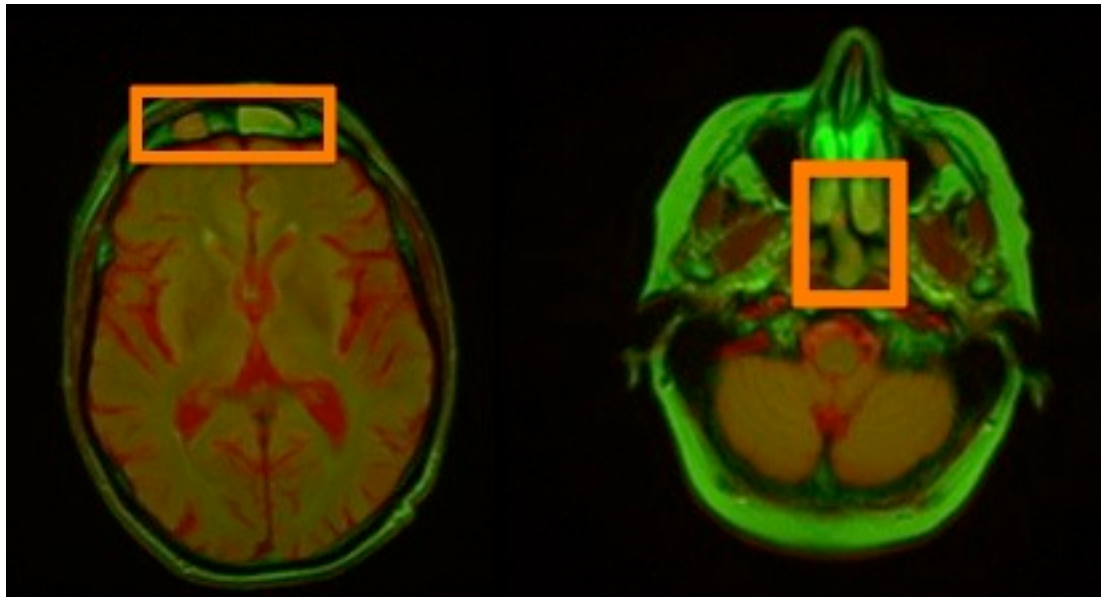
Fused axial T2*W and FLAIR images showing the additional visual information used to distinguish non-brain features from brain tissue.
